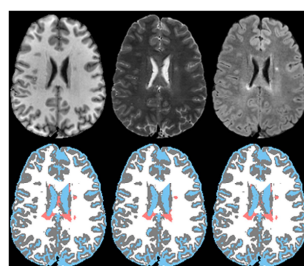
1st row: T1, T2, FLAIR; 2nd row: segmented, validated, improved images.
